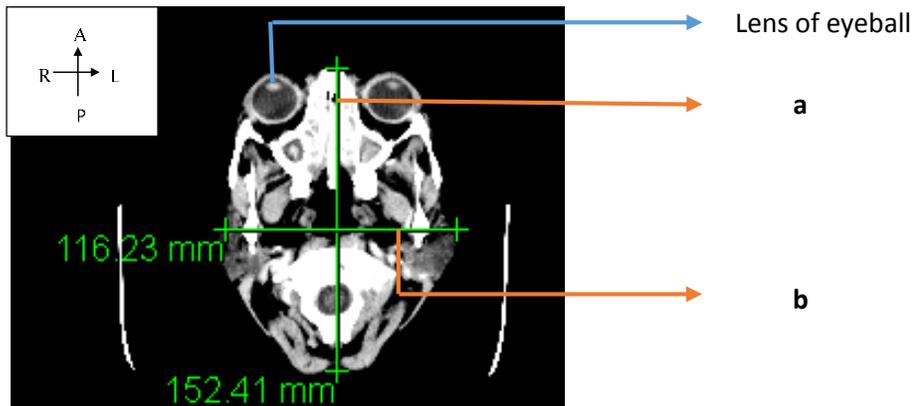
CT Brain- Measurements of Tomographic Image - At Level of Eyeball (Level B1)
